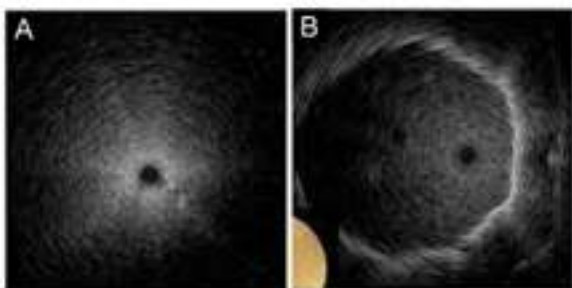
Radial Endobronchial Ultrasound image visualizing 360 view of A-normal lung parenchyma and B-View from within the tumour
